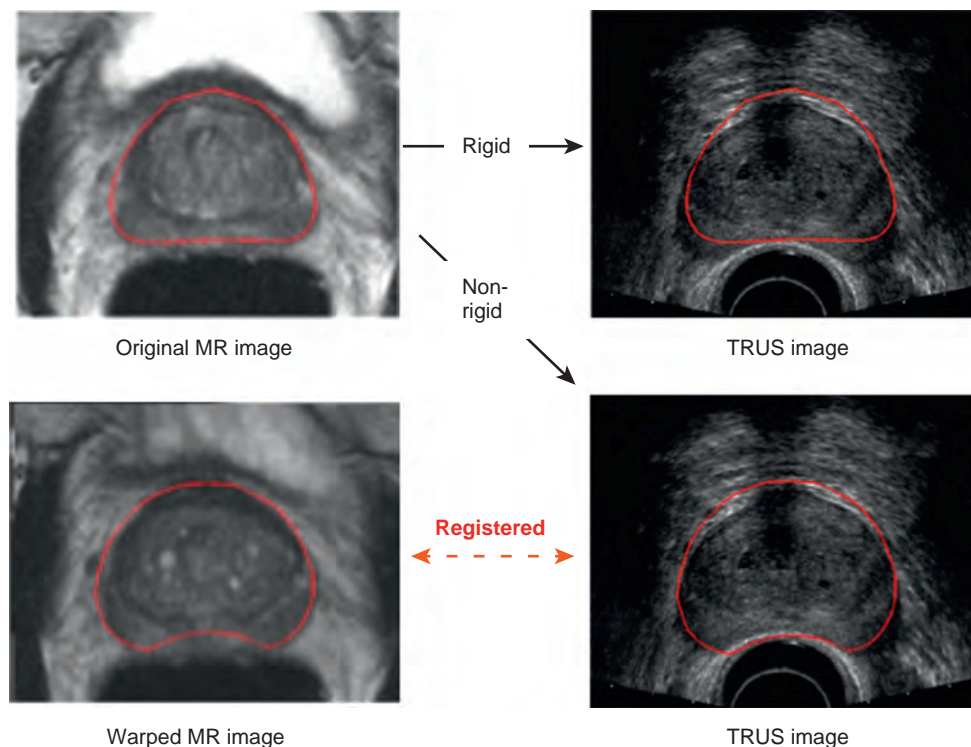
Targeted biopsies using fusion software can be carried out using either rigid or nonrigid fusion. The error for the rigid fusion is approximately 5 mm and for the nonrigid fusion approximately 2.5 mm. MR, magnetic resonance; TRUS, transrectal ultrasonography. (Courtesy Yipeng Hu and Dean Barratt, UCL SmartTarget.)
